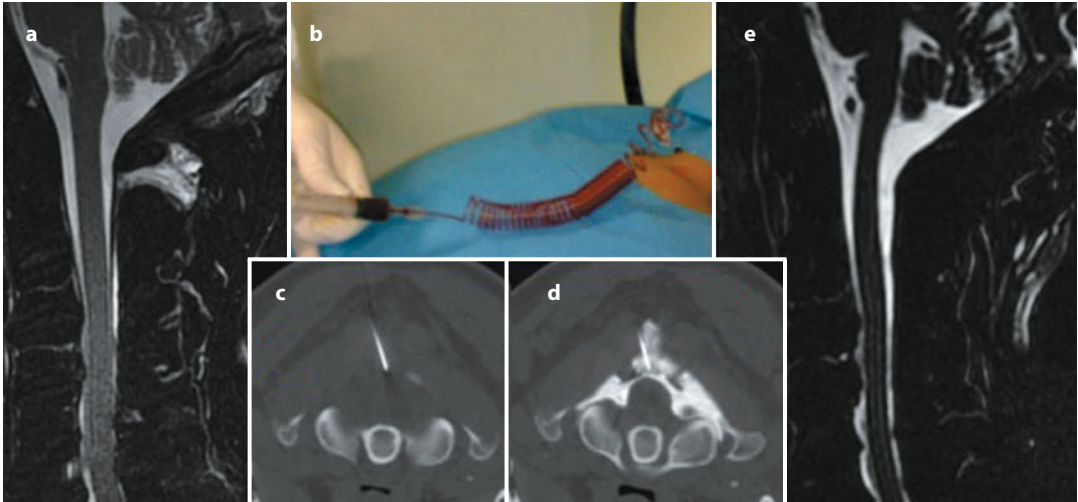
Autologous dural blood patch in a patient with dural fistula at the C1–C2 level. MRI (sagittal plane), T2-weighted fat saturated turbo spin echo: evidence of leakage of cerebrospinal fluid in the posterior wall (a). Injection of unclotted blood (b). Needle placement under CT control (c). CT showing the injection of 10 cm³ of autologous blood with 1 cm³ of contrast medium (d). MRI (sagittal plane), T2-weighted fat saturated turbo spin echo: control showing complete resolution of the fistula (e)
